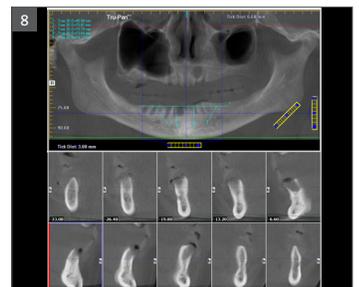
Implant preoperative CBCT.
